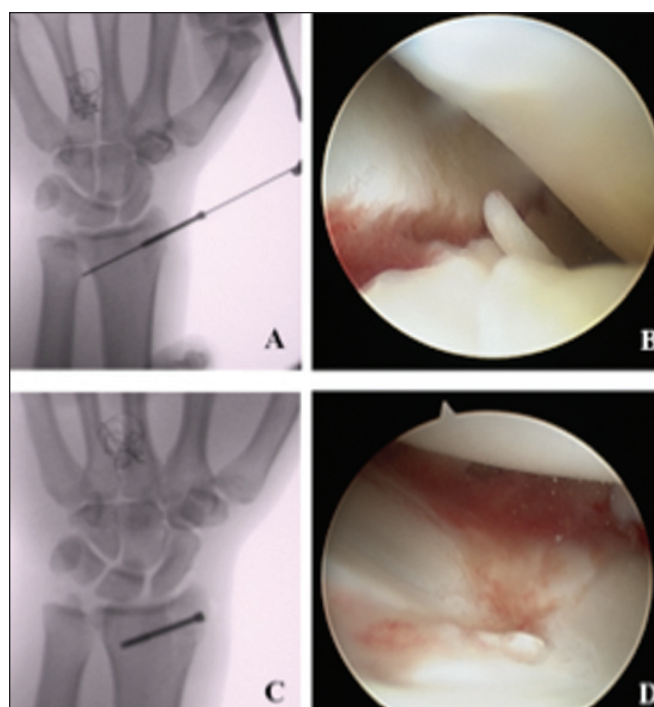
Arthroscopic-assisted distal radius fracture fixation. Cannulated headless compression screw fixation of a radial styloid fracture. The screw had been partially inserted and used as a joystick for styloid reduction under arthroscopic visualization (A). A greater than 2-mm gaping fracture prior to reduction and fixation (B). Radiograph after accomplished fixation (C). The reduced and compressed fracture (D).
